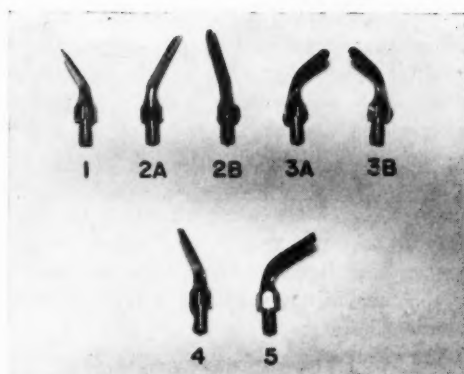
Ultrasonic scaling points
